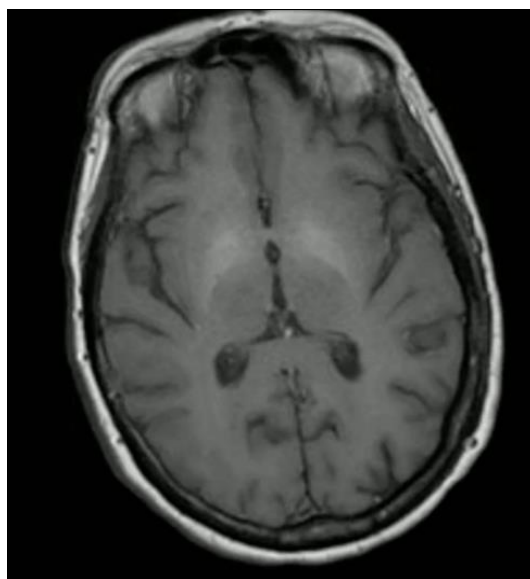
Chronic hepatic encephalopathy imaging findings. Axial T1-weighted image demonstrates characteristic bilateral symmetric T1 hyperintensity within the globus pallidi, a hallmark of manganese deposition secondary to impaired hepatic metabolism in chronic liver disease. This finding is pathognomonic for chronic hepatic dysfunction.
